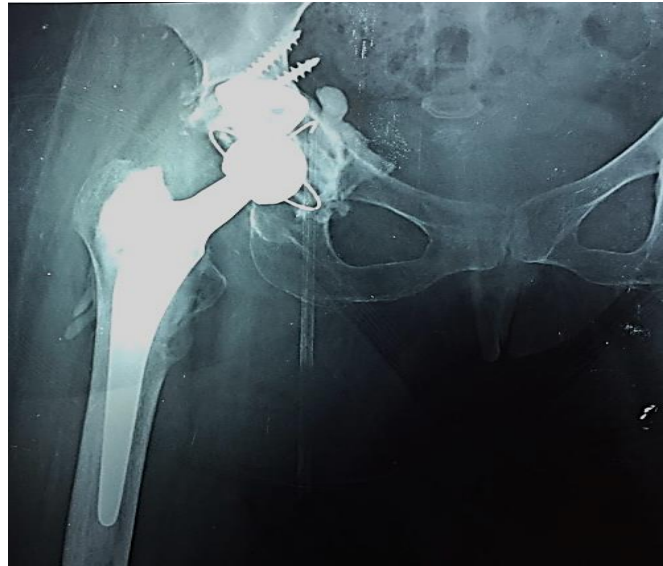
follow up x-ray after 6 weeks
